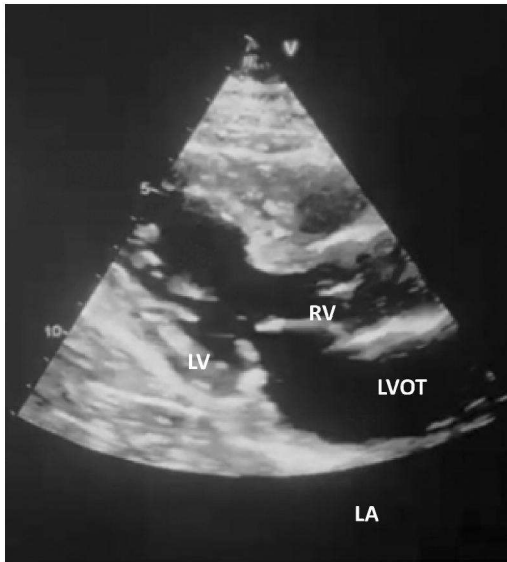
Parasternal long view, with the left atrium (LA), left ventricle (LV), left ventricular outflow tract (LVOT) and right ventricle (RV) seen.
